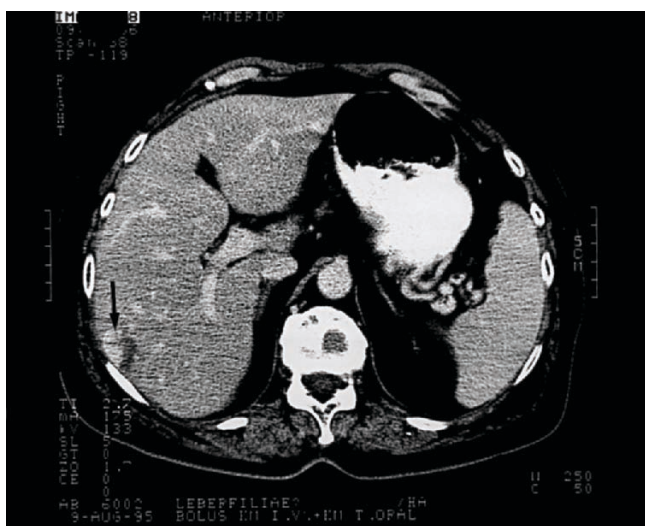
Haemangioma (see arrow). Dynamic CT (contrast-enhanced); portal venous phase (s. figs. 6.18; 8.9; 36.7–36.9)
